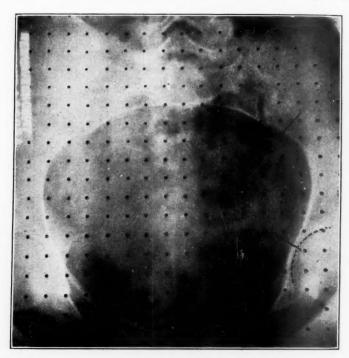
Roentgenogram showing division of pubic and iliac portions. Dots represent corrected centimeters in the plane of the superior strait.
